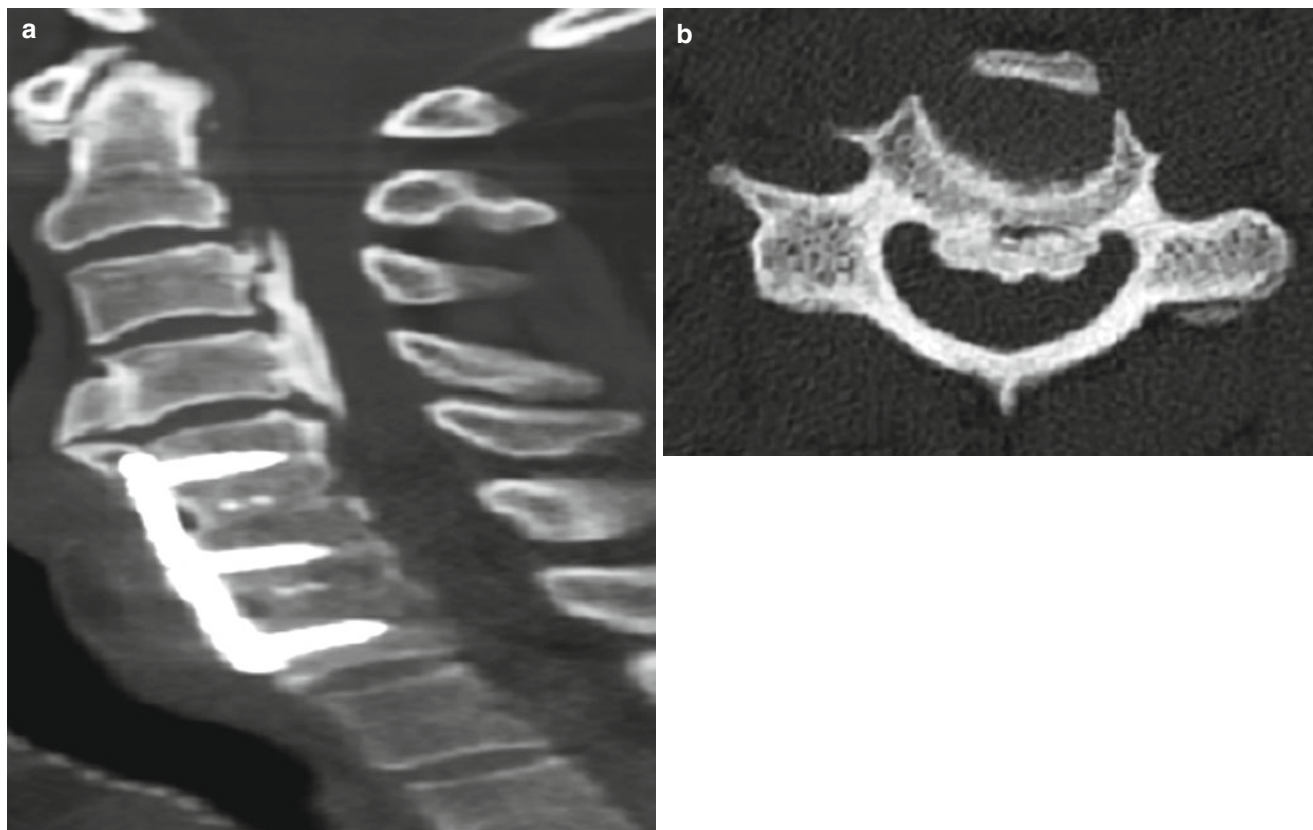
(a, b) Preoperative CT scan image demonstrates severe spinal cord compression behind the vertebral body of C3–4 secondary to ossification of the posterior longitudinal ligament, which had formed
